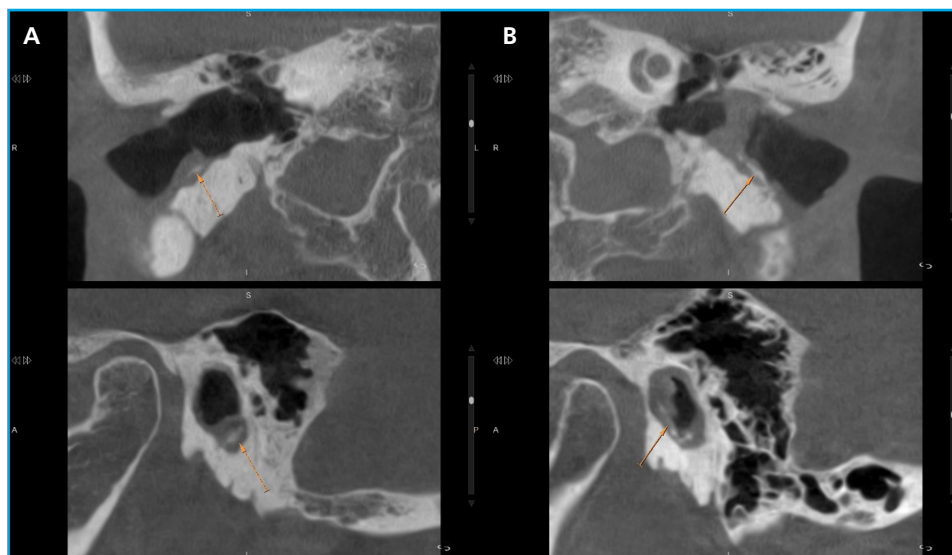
Cone beam computed tomography (CBCT). Coronal and sagittal reconstructions of both external auditory canals (EACs). Moderate stenosis of both external auditory canals (A: right; B: left) due to circumferential soft tissue (likely necrotic skin) and within this, fragmentation and bone sequestra (orange arrows) of the bony cortex. Findings are more prominent on the left side.
